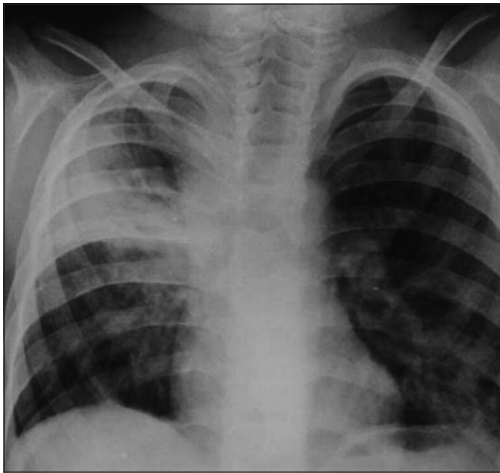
Chest radiograph at admission showed consolidation in posterior segment of right upper lobe
